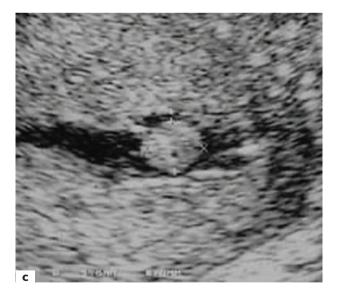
A 45-year-old patient with metrorrhagia. (a) Transvaginal sonography shows a normal appearance and thickness of the endometrium; (b) and (c) saline infusion sonohysterography provides visualization of a small fundal polyp
